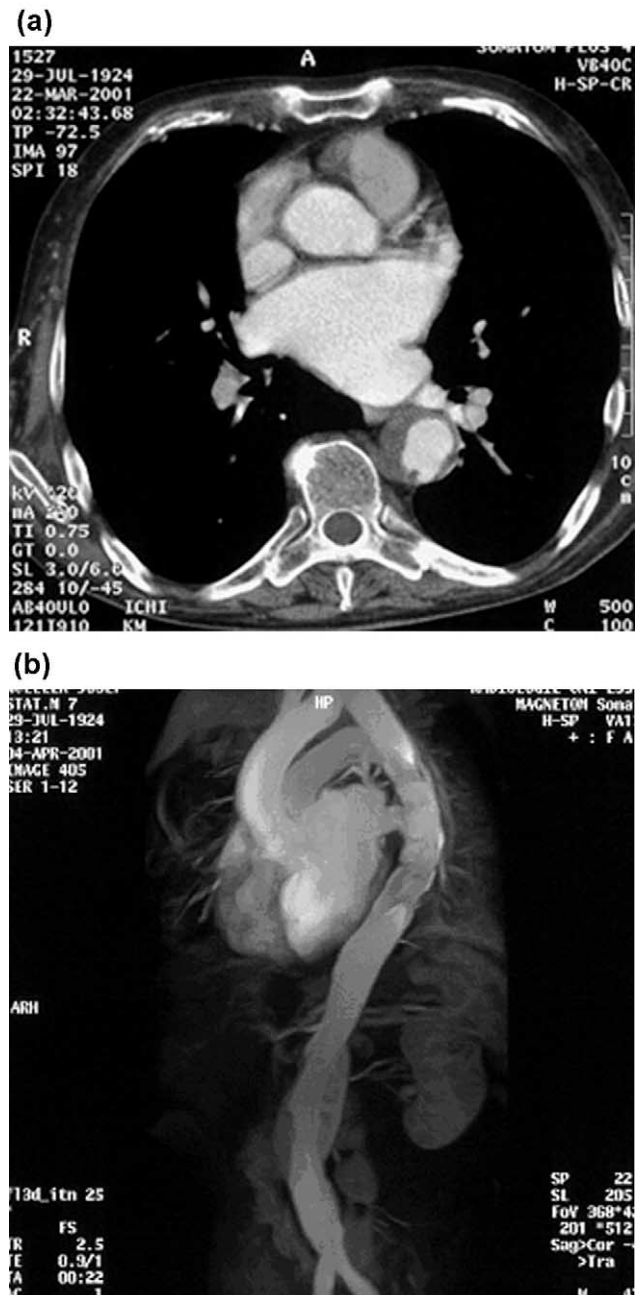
Seventy-six-year-old symptomatic male patient with a ruptured aortic plaque shown on computed tomograph (CT) (a). Control magnetic resonance image shows a stable position of the stent graft and sealing of the aortic lesion (b).
